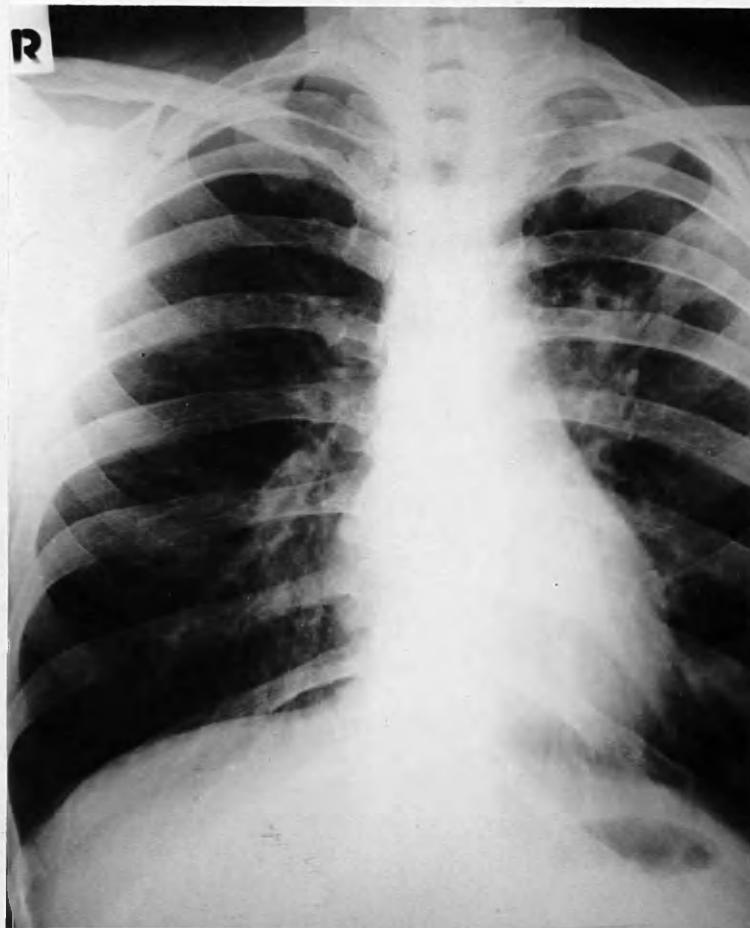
Radiograph taken on 18.11.52. A thick-walled cavity is present in the left upper zone with "tramlines" running thence to hilum.
